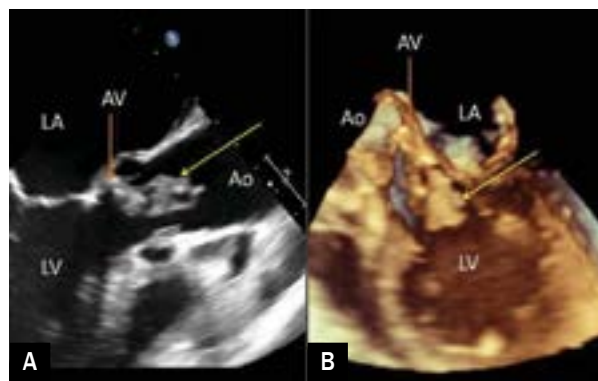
Aortic valve (AV) endocarditis: very large vegetation attached to the AV (yellow arrow); A. Two-dimensional (2D) transoesophageal echocardiography (TEE); B. Three-dimensional (3D) TEE; Ao – aorta; LA – left atrium; LV – left ventricle
